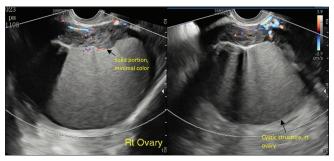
Transvaginal ultrasound showing a unilocular cyst in the right adnexa, thought to be the right ovary, containing low-level internal echoes, described as "ground glass," characteristic of an endometrial cyst (seen in 95% of cases). Within the cyst is a solid component with posterior acoustic shadowing and minimal color on flow mapping
